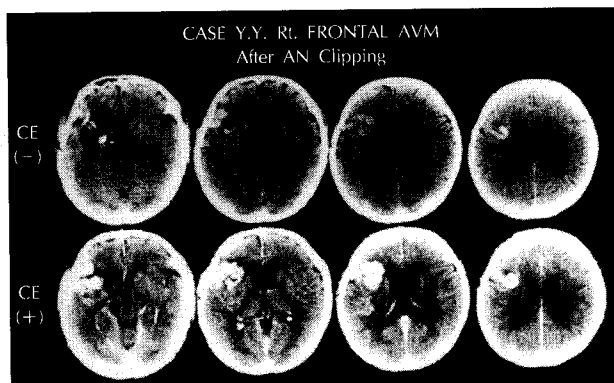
Head CT scan before embolization of the case 1. Without (upper row) and with (lower row) contrast enhancement.
